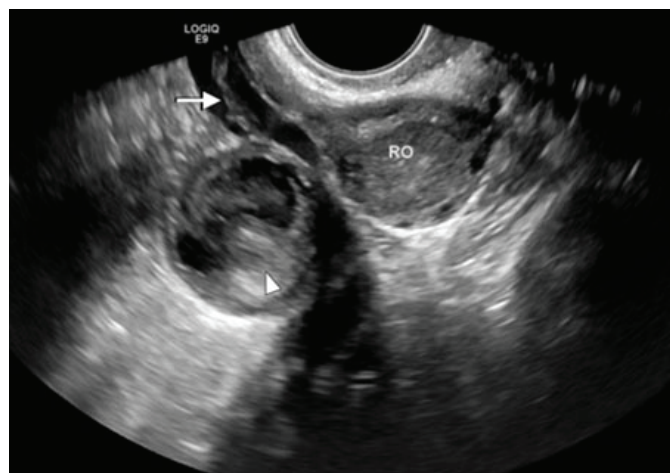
Transvaginal ultrasound of the right adnexa. The right ovary is marked "RO" and the adnexal mass is indicated by the white arrowhead. The iliac vasculature is demonstrated with the white arrow.
